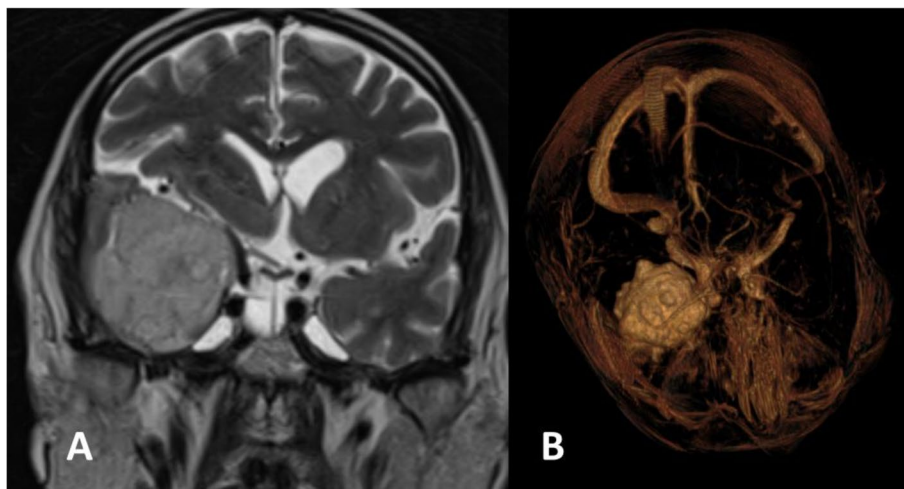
MRI imaging showing the meningioma A coronal T2 B volume T1 with gadolinium injection
